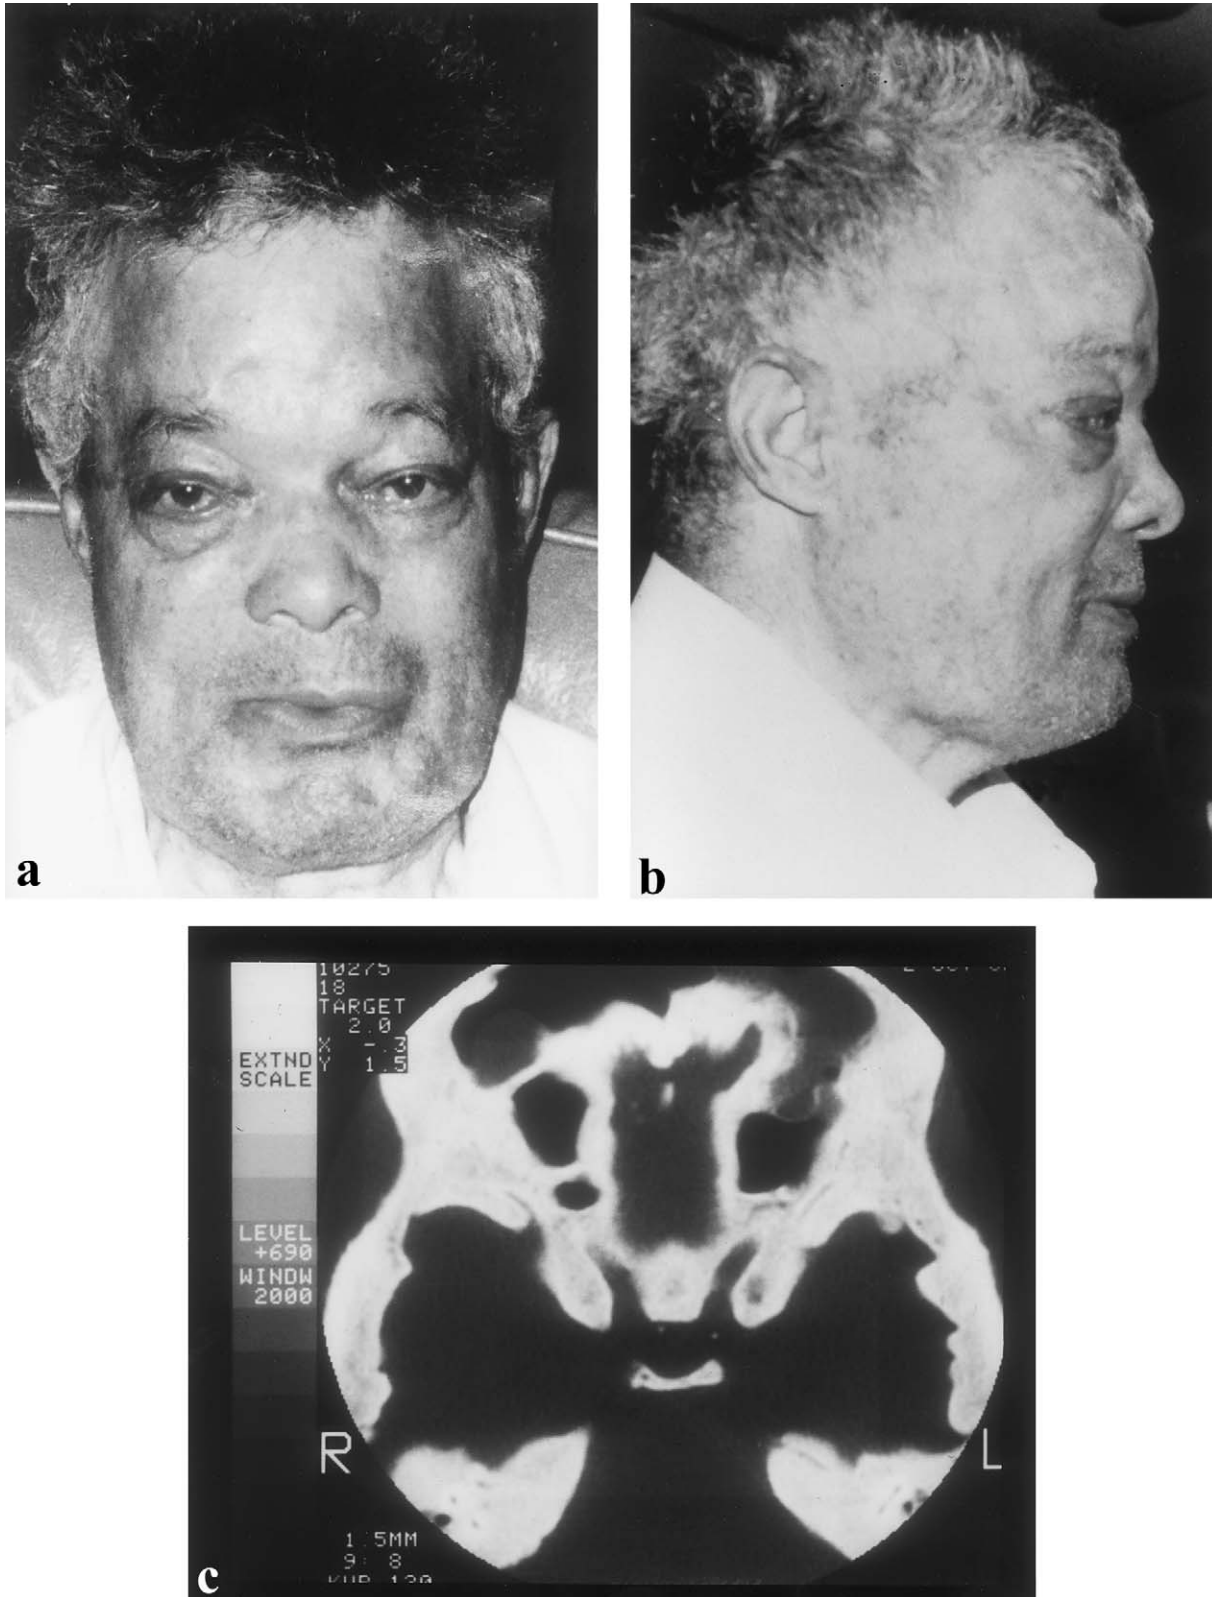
Clinical pictures and CT scan of an American patient V-2 showing characteristics of sclerosteosis. *a-b*, Frontal *a* and lateral *b* facial views. *c*, CT scan of posterior fossa, indicating extensive sclerosis and marked thickening of skull base, with obliteration of the diploic space. The frontal sinuses are well developed.
